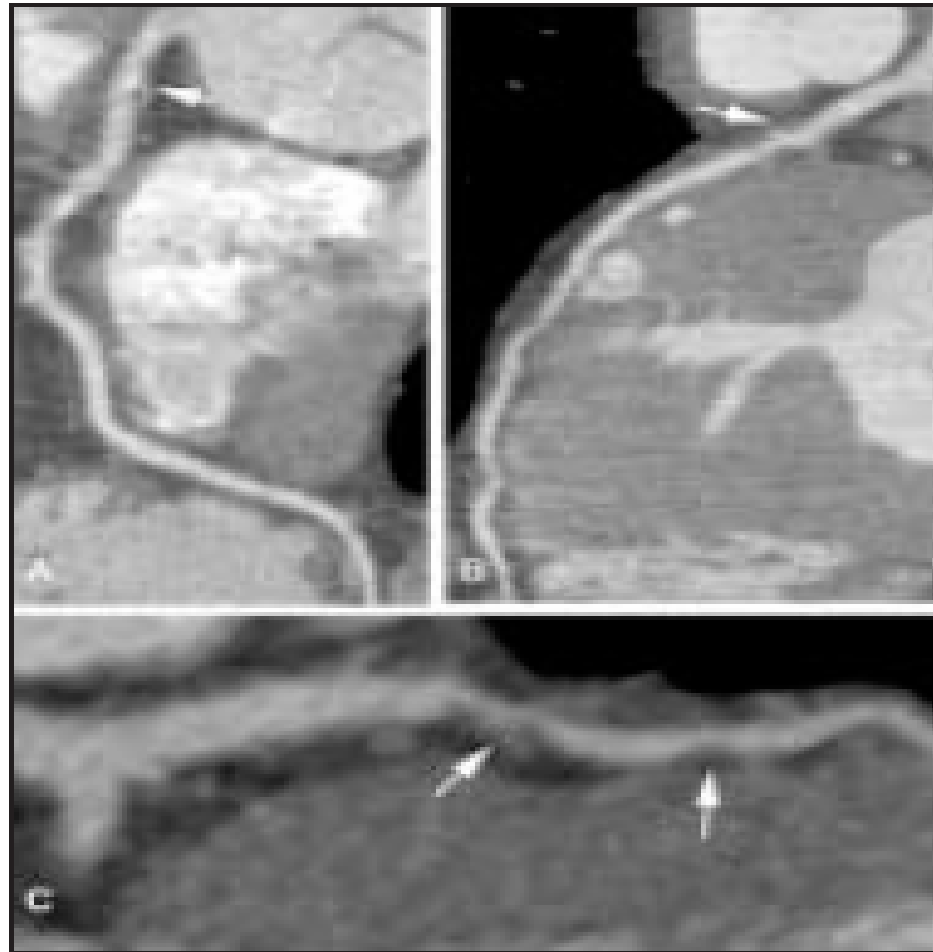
CT coronary angiogram demonstrating atherosclerotic plaques (arrows) in the right coronary (A), left anterior descending (B), and first diagonal (C) arteries. Patient had elevated cholesterol but was asymptomatic and had no previous diagnosis of CAD.
